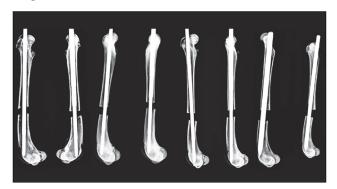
Post-procedure radiographs of the bone-pin construct in femur fracture gap models.
